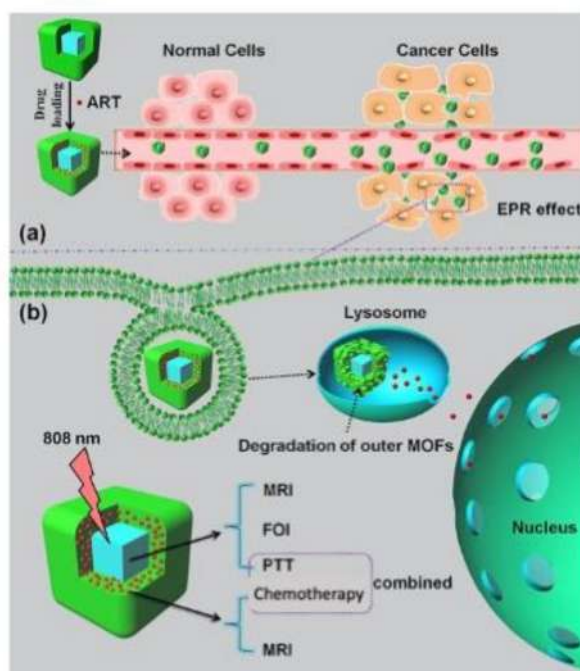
Picture of multifunctional nanoMOFs targeting tumors for combined therapy. (a) Loading and delivery process through the enhanced permeation and retention (EPR) effect. (b) pH-responsive degradation of outer magnetic nanoMOFs for drug release and dual-modal FOI- and MRI-guided cancer therapy in vitro and in vivo. Reprinted with permission from [69], copyright 2020 from Elsevier (Amsterdam, The Netherlands).
